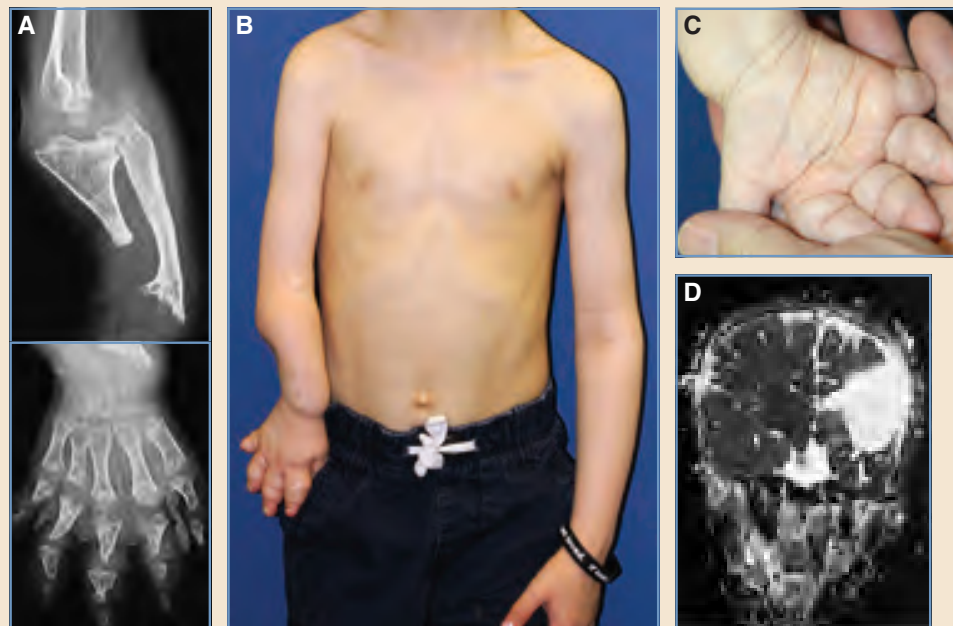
Type V defect with stroke. A and B, This child presented at 5 years 4 months of age with a marked length discrepancy of his right upper limb. He was born with a major ischemic injury and a large eschar on the dorsoulnar surface of the forearm, which healed spontaneously. The shoulder was high positioned. The elbow and wrist were unstable. He had good shoulder and elbow motion. The wrist was flail. Radiographs showed that, with growth, the distal ulna completely resorbed, and the radius became sclerotic with a deformed, angulated distal metaphysis. The phalanges had thin, pencil-like condyles and hypoplastic distal segments. C, The hand appeared swollen and was much smaller than the opposite hand. Although the hand wrinkled in water, he had diminished sensation in the medial nerve distribution. D, An MRI T2-weighted scan showed an ischemic defect in the distribution of the middle cerebral artery.
